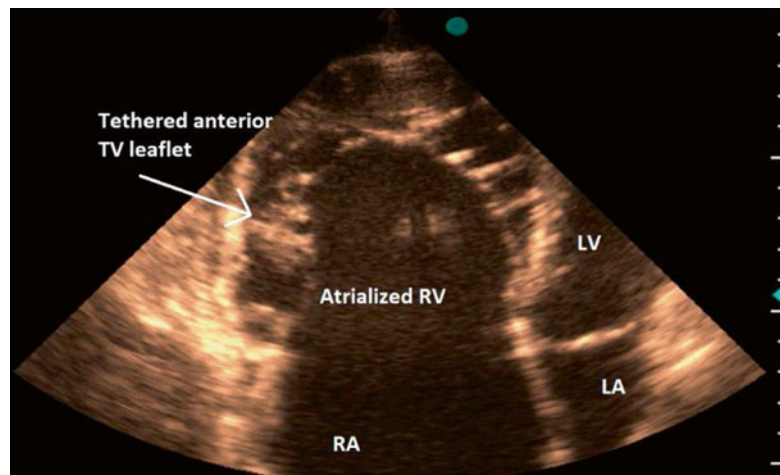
(a, b) Apical four-chamber view in a typical Ebstein anomaly showing increased apical displacement of septal TV leaflet compared to the mitral leaflet insertion and tethered anterior TV leaflet. *TV* tricuspid valve, *FRV* functional right ventricle, *RA* right atrium, *LA* left atrium (Video 26.2)
